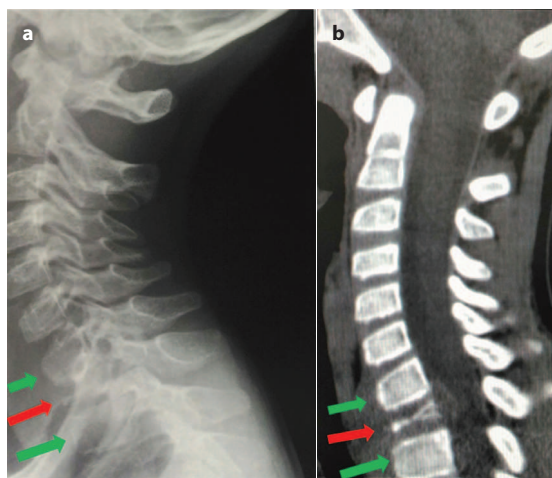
Cervical spine X-ray and computed tomography (CT) (sagittal view) that reveals T₁ vertebra flattening (red arrow). Notice the normal height of the neighbouring C₇ and T₂ vertebrae (green arrows).
